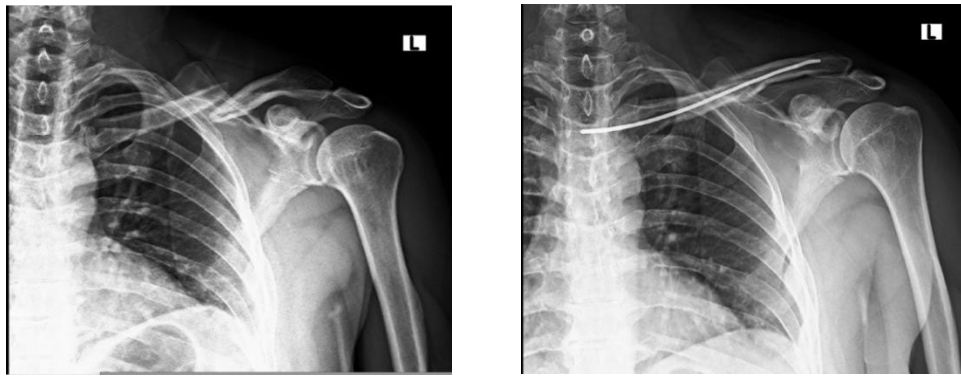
Pre-Operative & 5 month follow up X-Rays of a 22-year-old male patient with AO Type B1 Left Midshaft clavicle fracture
